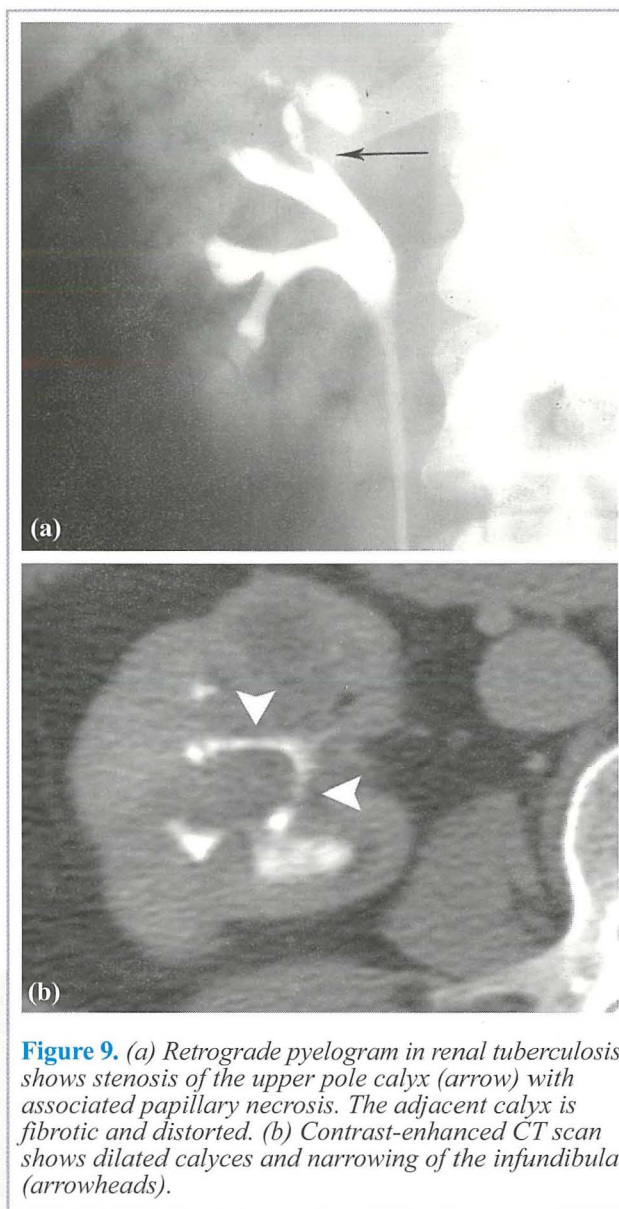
(a) Retrograde pyelogram in renal tuberculosis shows stenosis of the upper pole calyx (arrow) with associated papillary necrosis. The adjacent calyx is fibrotic and distorted. (b) Contrast-enhanced CT scan shows dilated calyces and narrowing of the infundibula (arrowheads).
